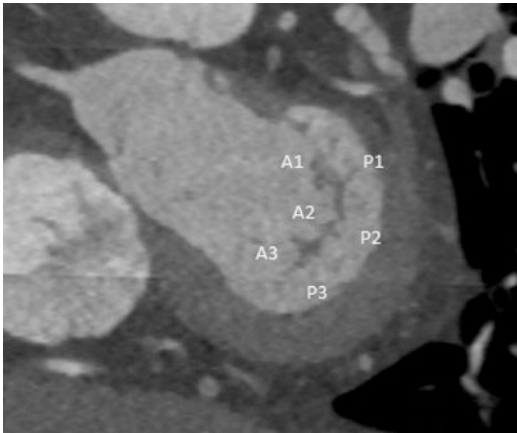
Short axis view on CT showing the coaptation of the anterior and posterior leaflets and cusps. The location of pathology is communicated using this cusp nomenclature
